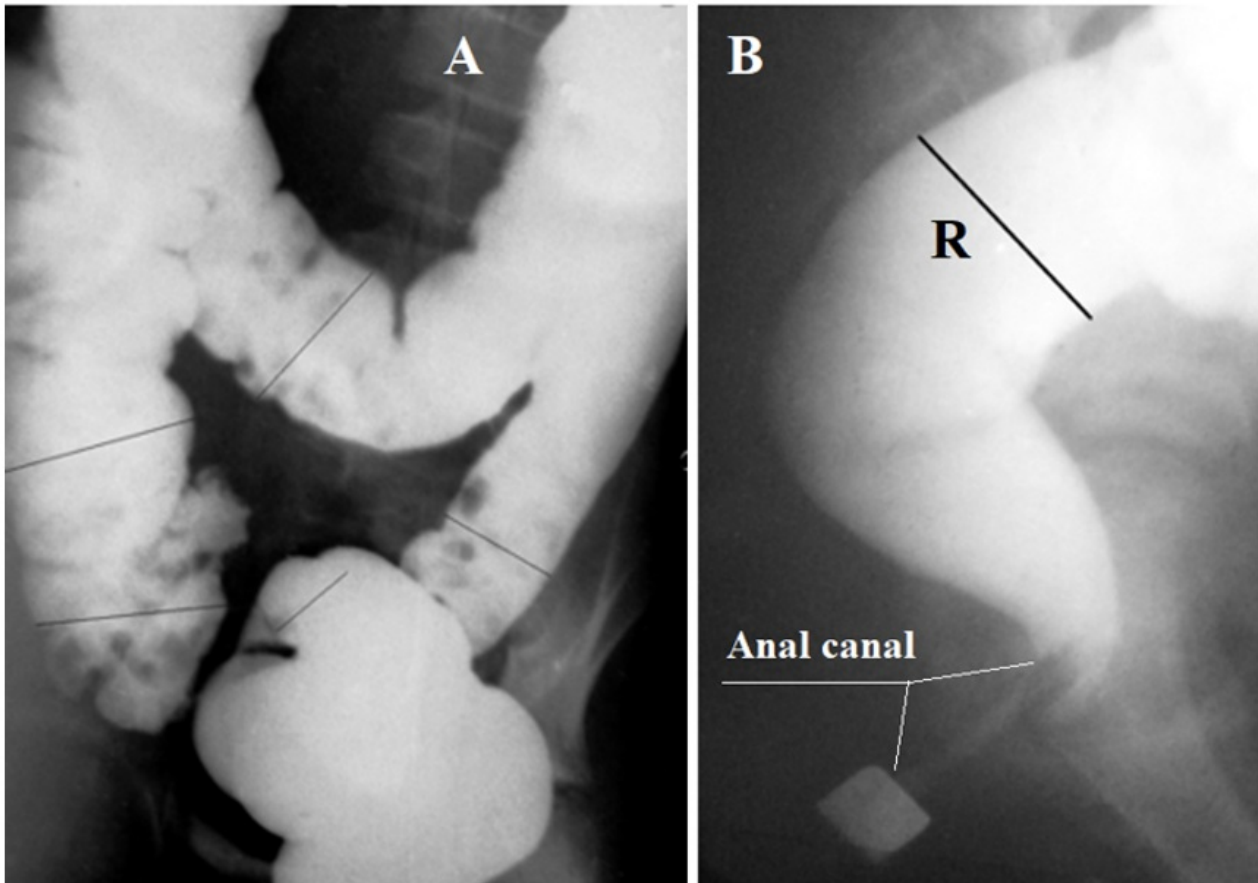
Frontal (A) and lateral (B) radiographs taken during a barium enema. On the frontal radiograph, you can measure all parts of the colon, except for the rectum. Only on the lateral radiograph of the anorectum can one measure the width of the vertical part of the rectum and the length of the anal canal from the rectum to the marker near the anal fossa. Knowing the diameter of the contrast marker, one can calculate the true width of the rectum (R) and the length of the anal canal.
